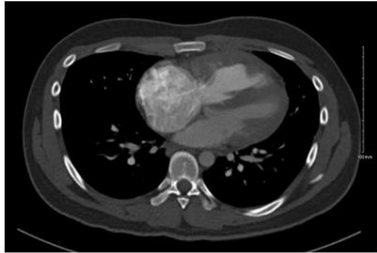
CT scan demonstrating RV hypertrophy
